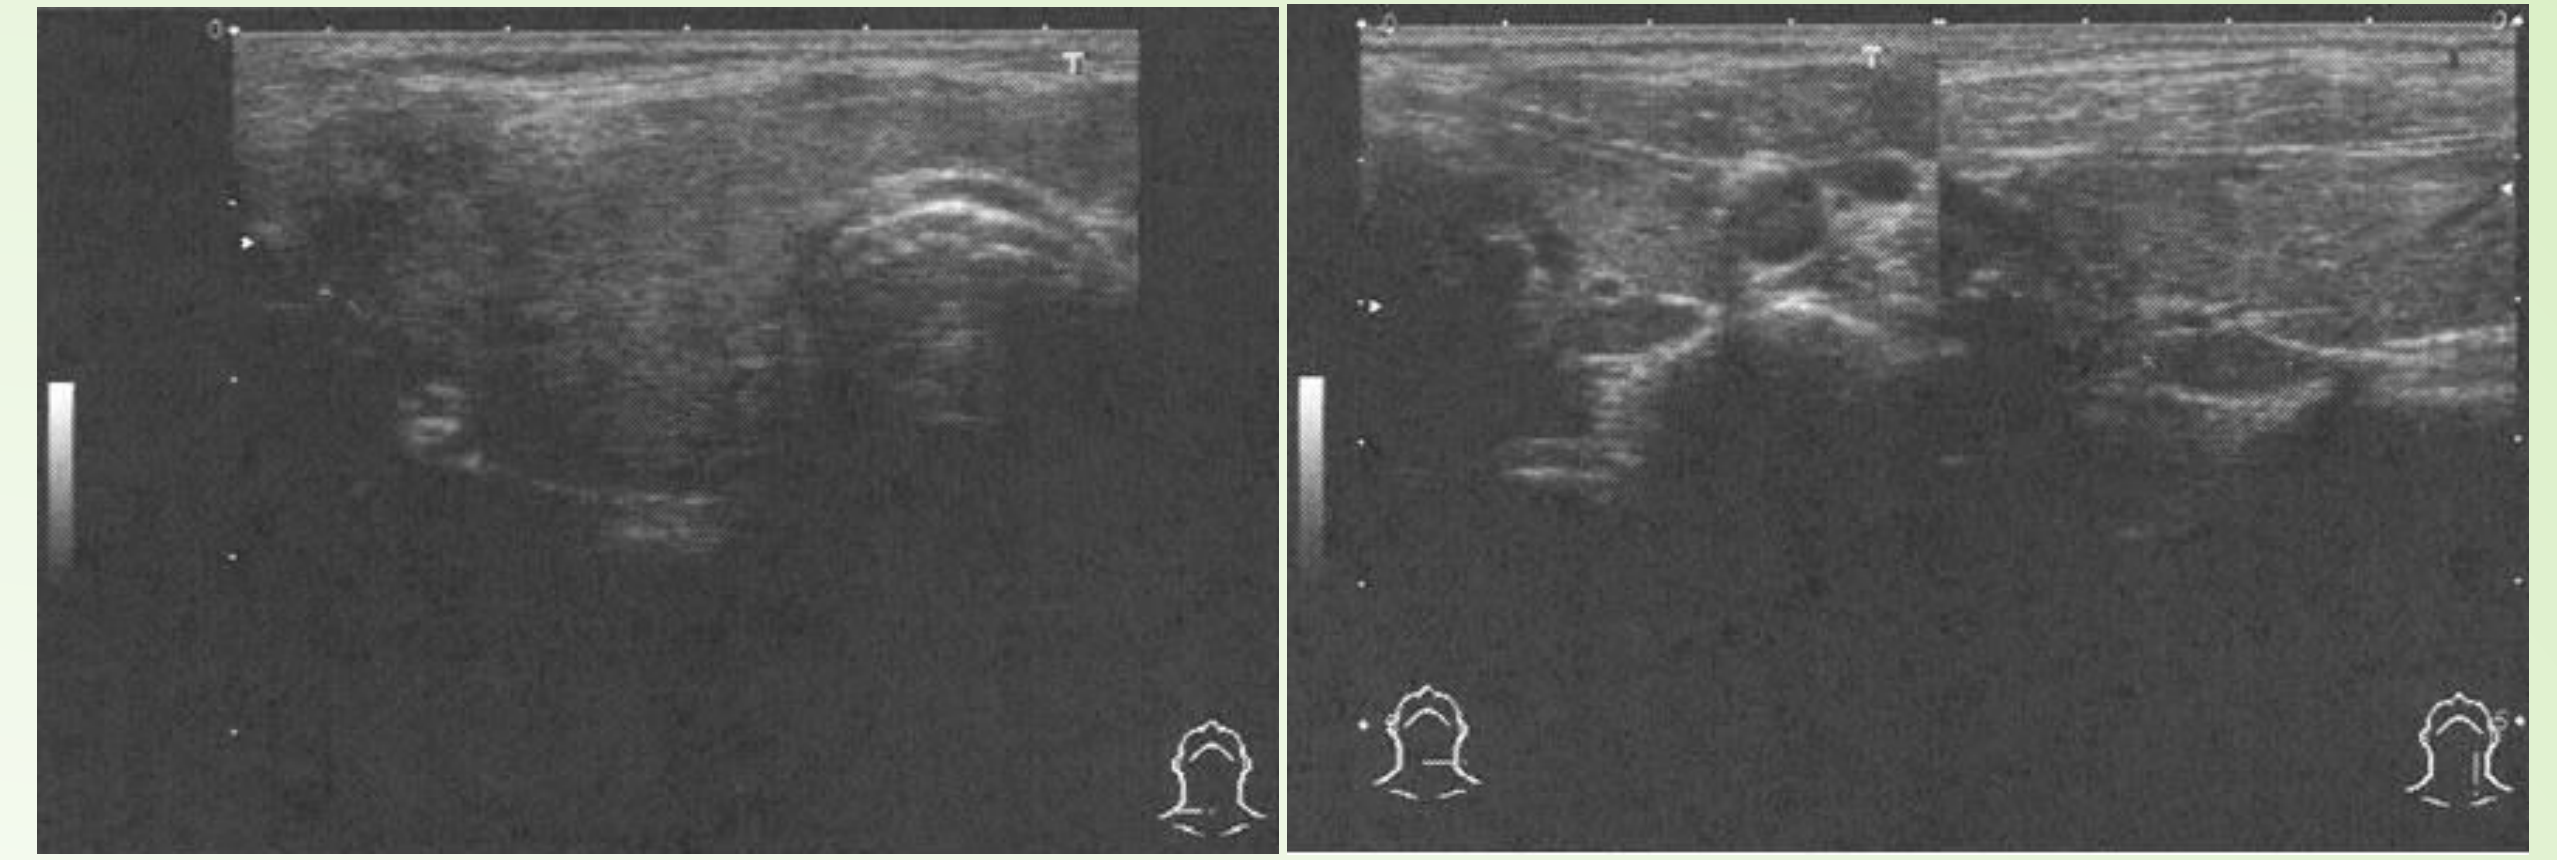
Thyroid swelling by cervical ultrasonography.
